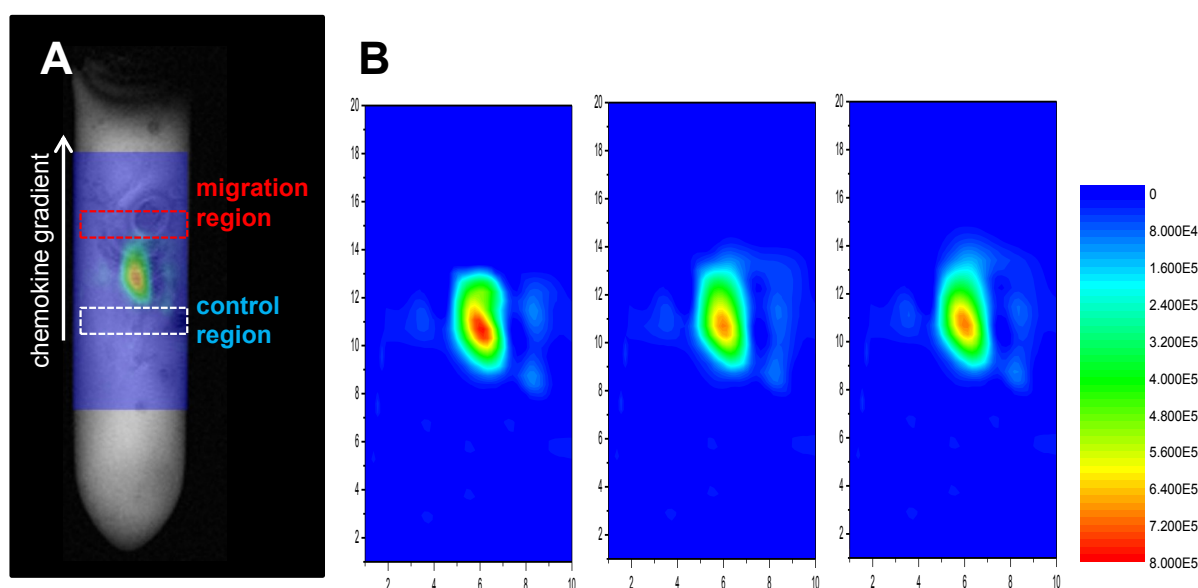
In vitro* model to study migration of small numbers of cells. (A) Cell bolus position within the sample. Overlay of a ^1H MRI image and ^{19}F CSI cell map showing the position and the density of the cell bolus injection in the tissue sample. The migration region is vertically above the cell pellet and the control region below. (B) The panels show representative data obtained at 1, 5 and 9 hrs after injection of 5×10^6 DCs. The scale bar represents the number of cells.
